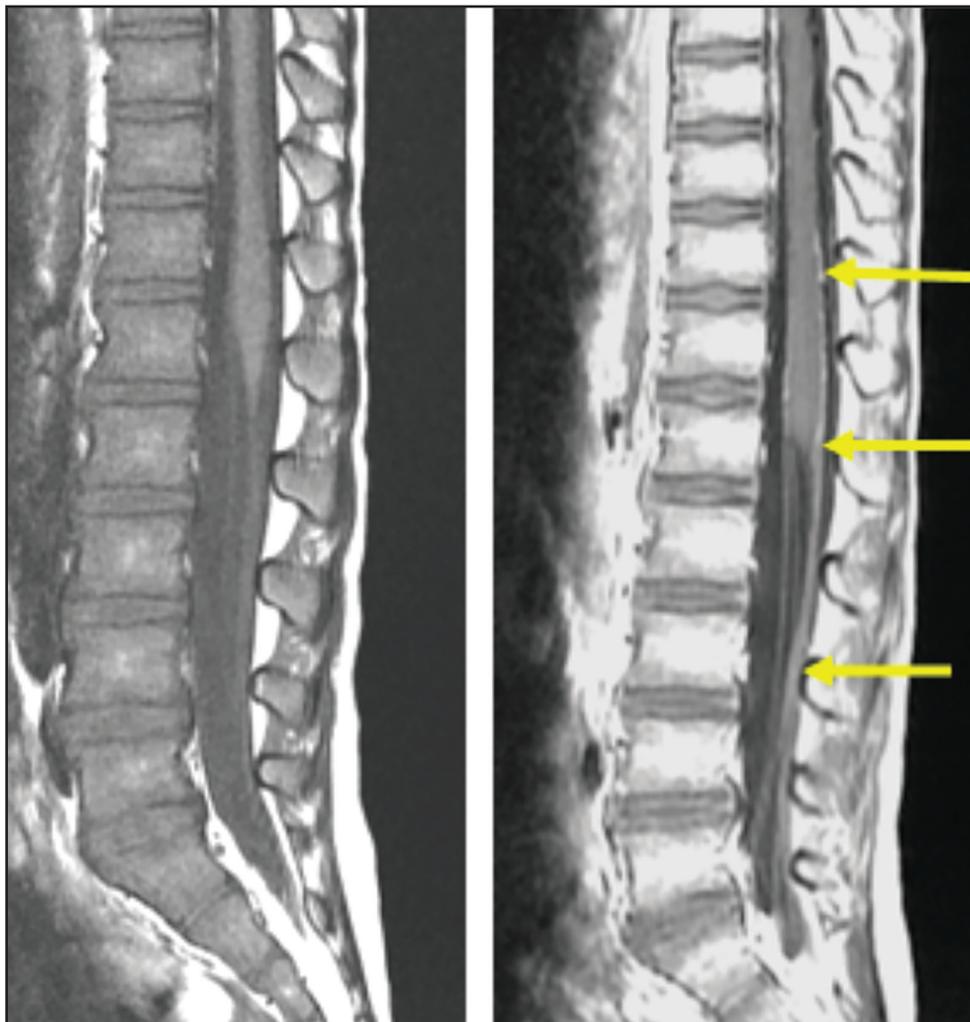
Contrast-enhanced MR image of the spine of a 24-month-old child with leptomeningeal drop-metastases from medulloblastoma (2.2 mL Dotarem [gadoterate meglumine]). Image courtesy of Prof. G. Sebag.
